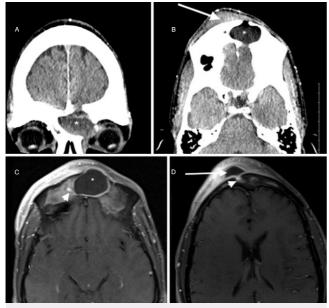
Imaging performed at initial presentation. A: CT showing a cystic mass expanding the left frontal sinus (*asterisk*). B: CT showing right frontal scalp fluid collection (*arrow*) with defects in the anterior and posterior wall of the left frontal sinus. C and D: MRI showing $2.7 \times 3.0 \times 4.0$ –cm cystic lesion expanding the left frontal sinus (*asterisk*) with diffusion restriction (not shown) and a sinus tract (*arrowheads*) connecting to a $1.8 \times 1.2 \times 1.1$ –cm frontal soft tissue fluid collection (*arrow*). There is also mild bone marrow enhancement. These findings indicate an infected mucocele, osteomyelitis, and frontal soft tissue abscess with a connecting sinus tract. In constellation with findings of bony defects on CT, this raises concern about an ECF.
